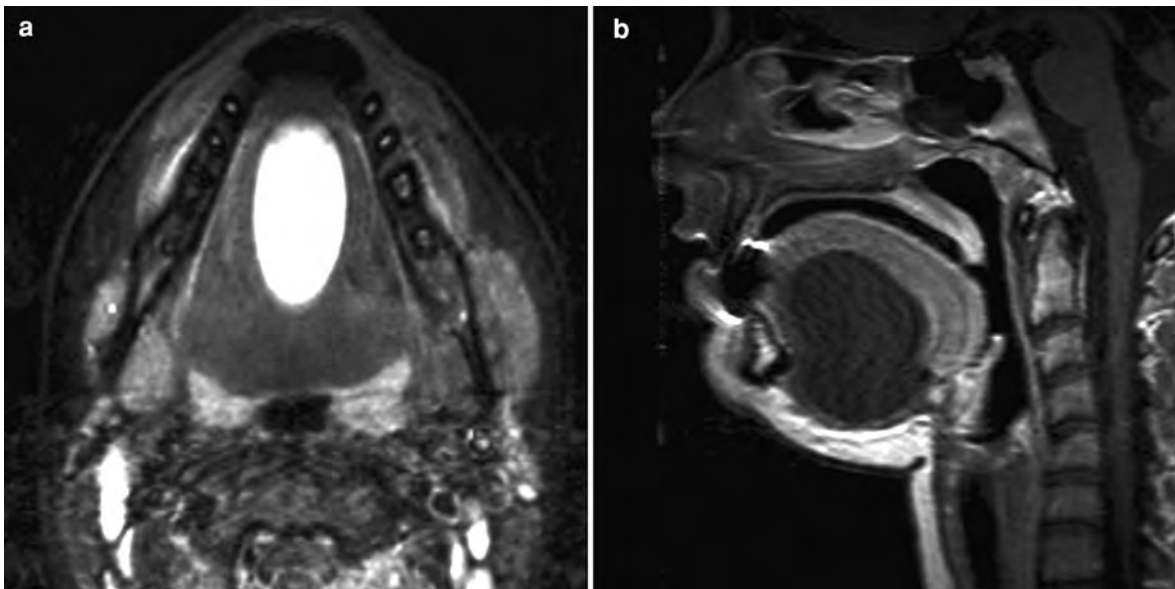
MRI of an epidermoid of the floor of the mouth and the tongue in a 21-year-old female. The lesion is strictly located in the midline. On T2, it presents well delineated with a very bright homogeneous signal (a). On post-contrast T1, there is no
